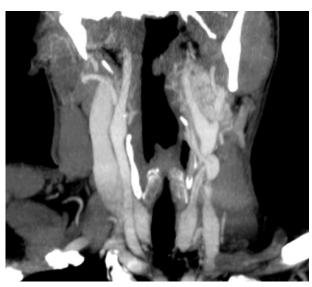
Coronal CT image of the neck shows characteristic splaying of the external carotid artery (ECA) and internal carotid artery (ICA) by a left hypervascular CBT.
